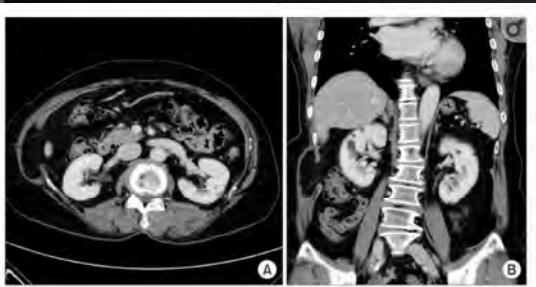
Radiologic findings of lateral abdominal wall defect. Abdominopelvic CT scan showed omental fat herniation through lateral abdominal wall defect of transversus abdominis muscle and internal oblique muscle (A) at right flank just below costal margin (B).
